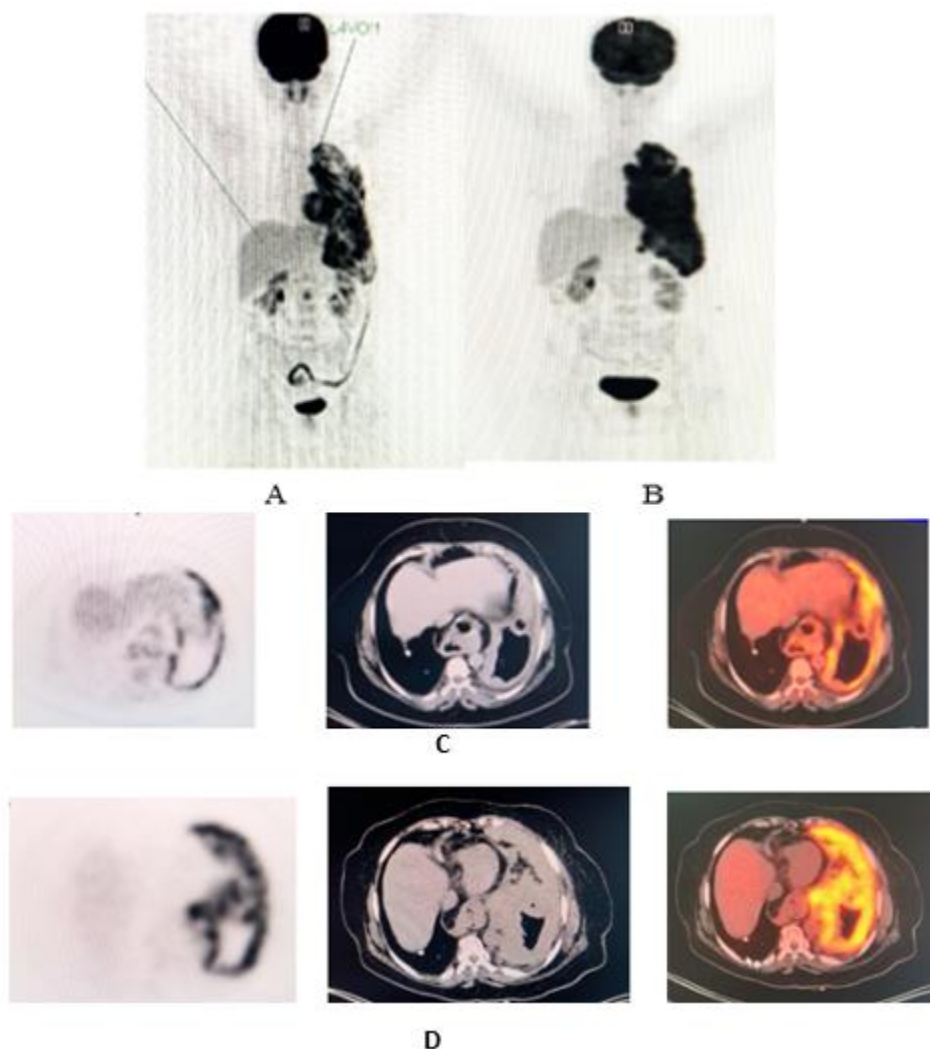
^{18}F FDG PET/CT whole-body maximum intensity projection image in initial stage (A) and axial initial ^{18}F FDG (PET, CT & fused PET/CT images) images (C) showing hyper-metabolic primary left pleural malignant mesothelioma, with Initial parameters SUVmax ~15.8 SUVmean~ 5.5 SUVpeak~12.8 MTV~1109 & TLG~6098.3. B & D = Follow up ^{18}F FDG PET/CT whole-body maximum intensity projection image (b) and axial ^{18}F (PET, CT & fused PET/CT images) showing evident disease progression.
